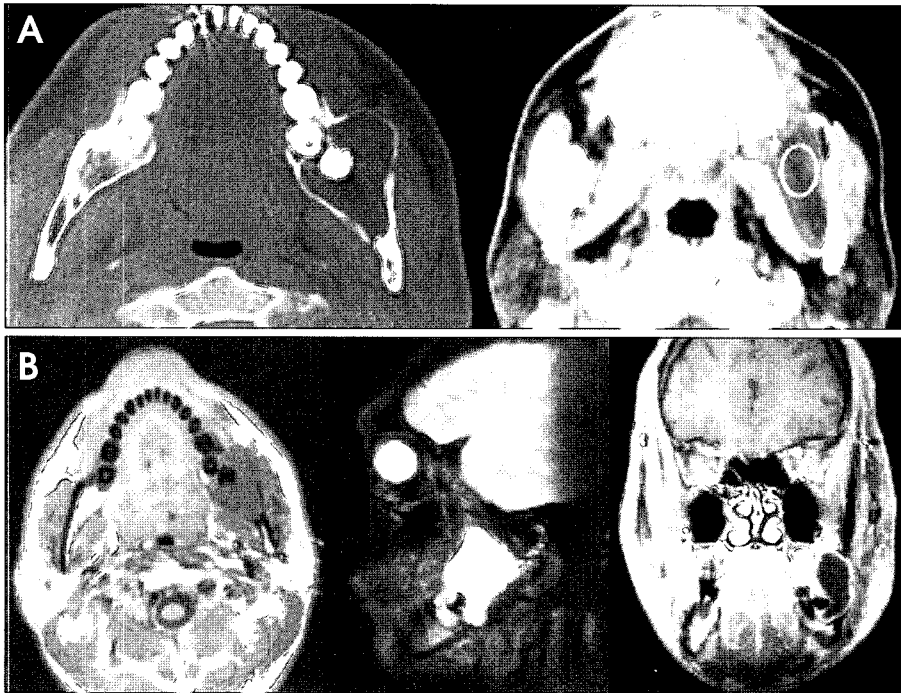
A: CT revealed 11 HU at the ROI and no internal structure. B: MRI shows a lesion of homogeneous low signal intensity on T1W1 and homogeneous extremely high signal intensity on T2W1. On Gd-T1W1, only the surrounding area of the lesion including the mural nodule and the thick wall shows rim enhancement except the central portion.
